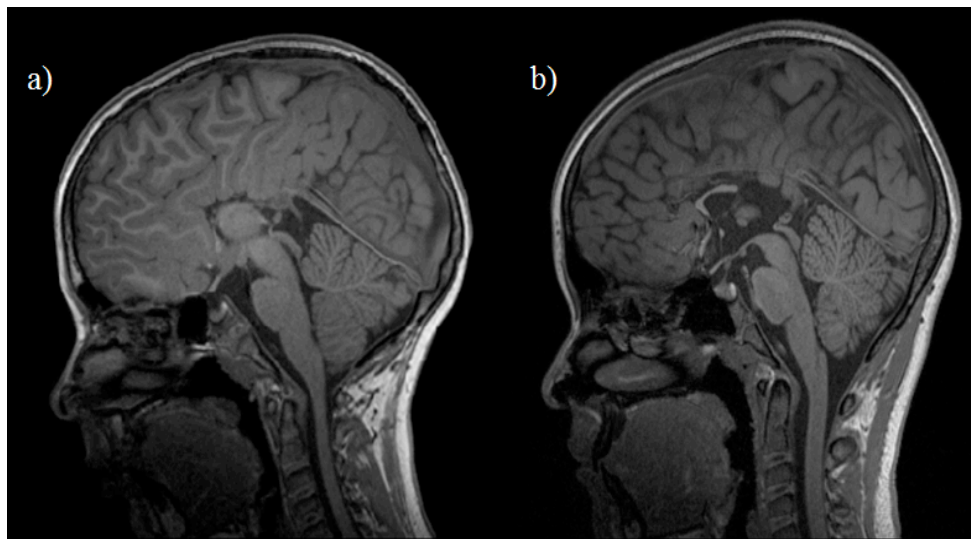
Midsagittal T1-weighted MRI of a) complete; and b) partial AgCC.
